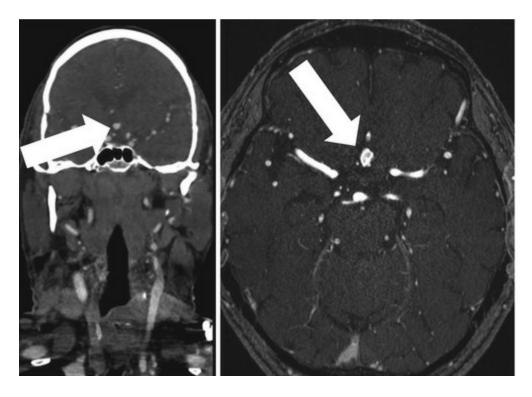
Incidentally detected aneurysm of the anterior communicating artery in a 62-year-old patient (*arrows*). The initial CT angiography scan (*left*) was performed for exclusion of vessel occlusion after hemiparesis and hyposthesia. MRA was performed subsequently for verification of the IF (*right image* TOF MRA)
